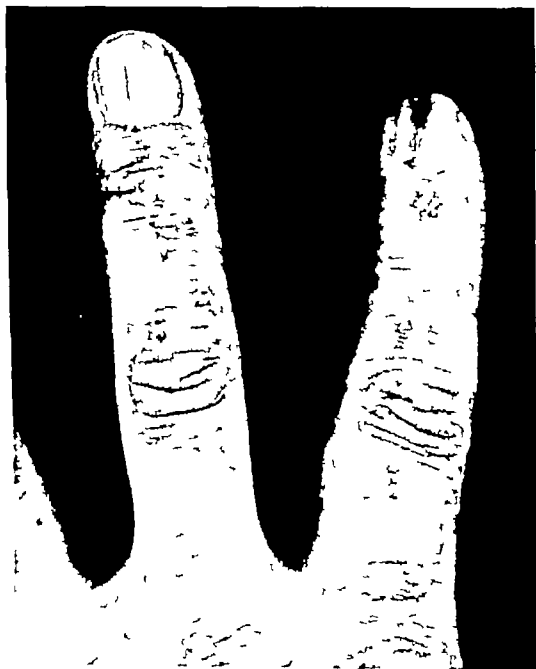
Case 11 Late irradiation changes in the fingers of a roentgenologist. Note the fissured nails, loss of pigment, the subungual hyperkeratosis and the ulcer at the base of the distal phalanx of the forefinger.
